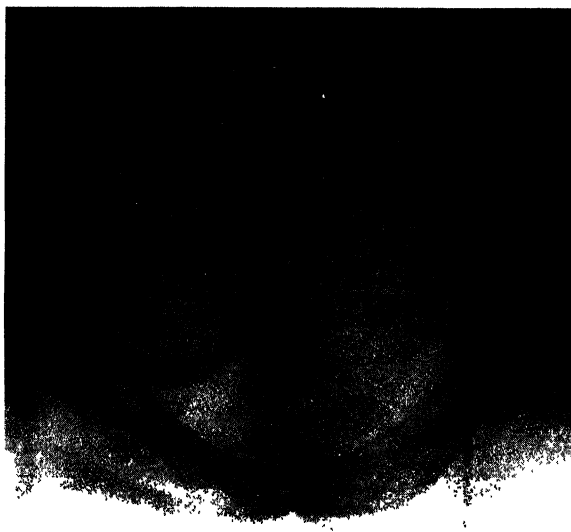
The generally contracted or small round pelvis; X-ray of inlet.
